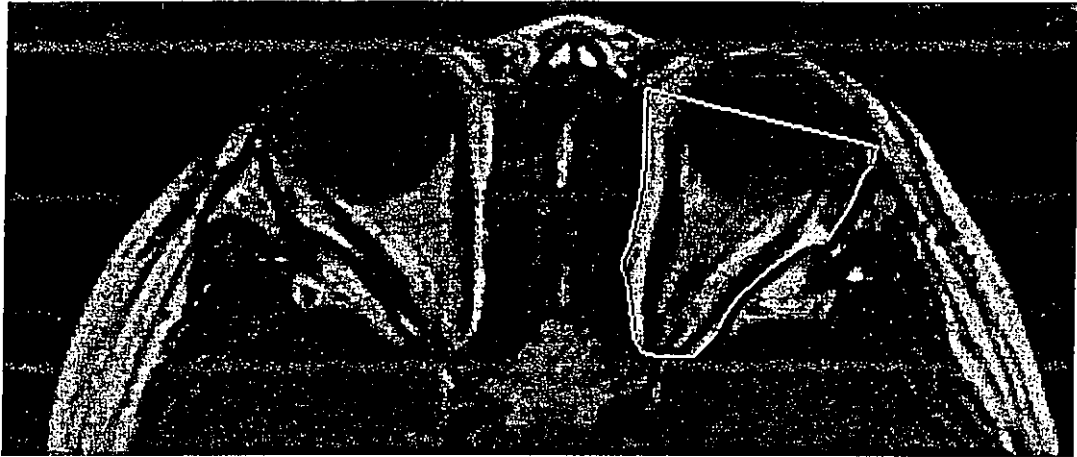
ROI was manually drawn around the left orbit border on an axial T1 MRI orbit image.
